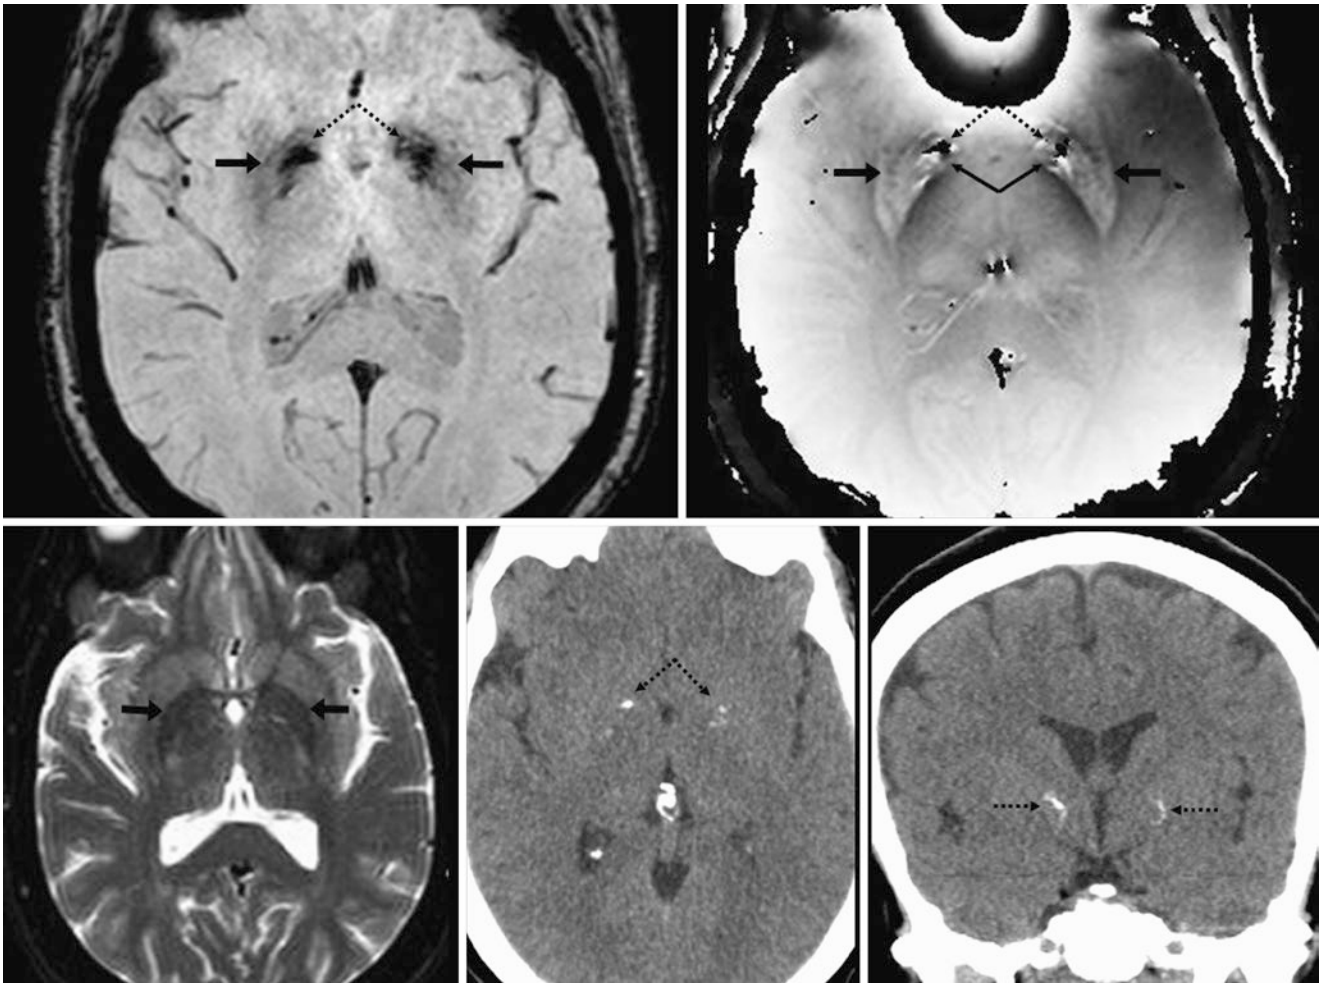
A 64 year old; on a 3T MRI (negative study), SWI (*top left*) shows dark signal from iron within the putamina (*arrows*), with smaller areas of dark signal within the GP (*dotted arrows*). An unfiltered phase map (*top right*) shows that the smaller foci of the dark signal centrally within the GP are diamagnetic calcium, while the larger areas of bright
